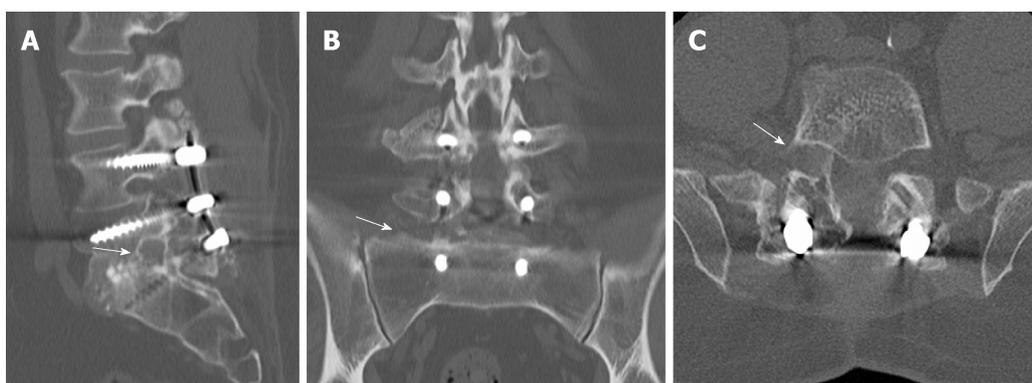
Postoperative computed tomography scan. A: Sagittal view showed the main part of the allograft spacer in the disc space without clear view of broken fragment; B: Coronal view shows obvious fragment (arrow) in the right L5-S1 foramina; C: Axial view also shows obvious fragment (arrow) in the right L5-S1 foramina.
